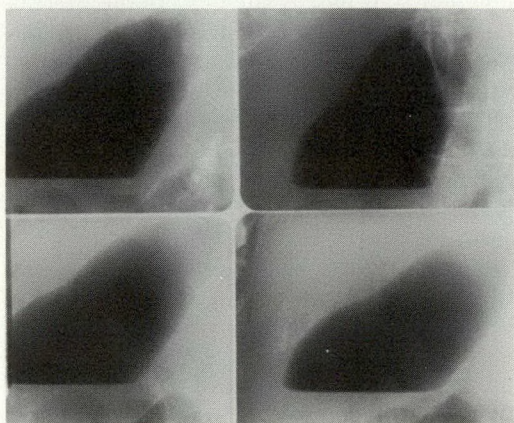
Cas no 2. Radiographie simple de l'abdomen en position debout centrée sur la région vésiculaire. On voit la vésicule biliaire remplie d'air avec un niveau liquidien.
